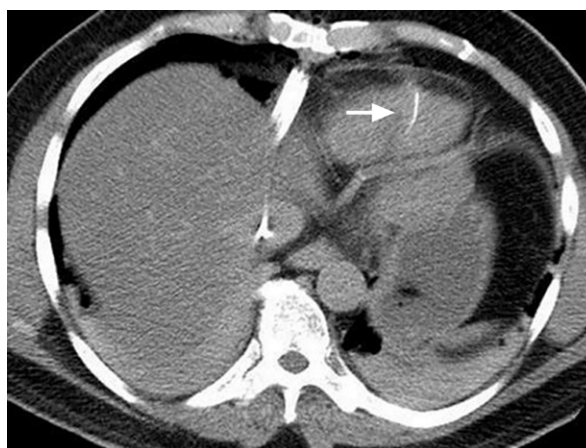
Computed tomogram of the chest and abdomen shows a fractured inferior vena cava filter strut (arrow) in the right ventricle.
